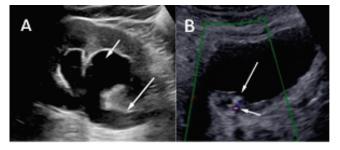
A patient with acute left-side loin pain. Emergency ultrasound shows moderate hydronephrosis (short arrow) and proximal hydroureter (long arrow).
